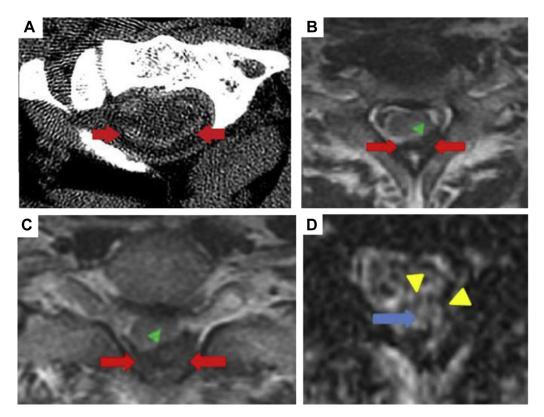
Axial CT image (A) demonstrates high-density material surrounding the cervical spine (red arrows), suspicious for subarachnoid hematoma. Two consecutive MR axial T2-weighted images (B and C) at the C6/C7 level demonstrate hypointense crescent-shaped signal (red arrows) compressing the cord posterolaterally (green arrows), consistent with subdural hematoma. GRE sequences of the lesion (D) show mixed signal intensity (blue arrow) with a hypointense rim (yellow arrows), indicating an early subacute hemorrhage with surrounding hemosiderin. CT, computed tomography; GRE, gradient echo.
